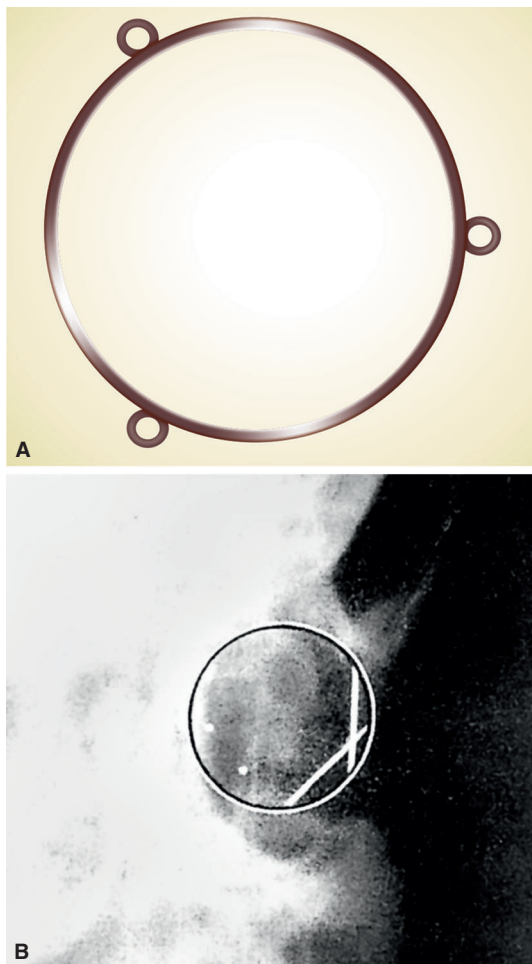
Limbal ring method of localizing RIOFB: (A) Limbal ring; (B) X-ray orbit lateral view with limbal ring.
